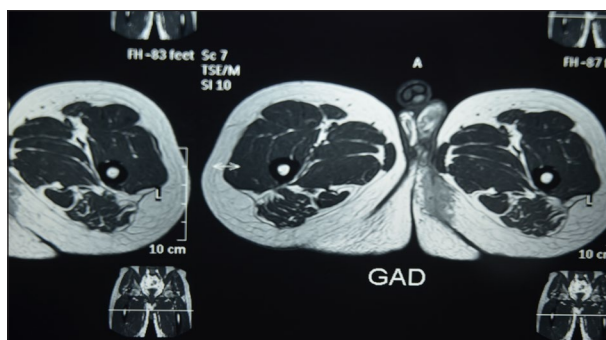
MRI showing the swelling involving the perineal and left side of the scrotum.
